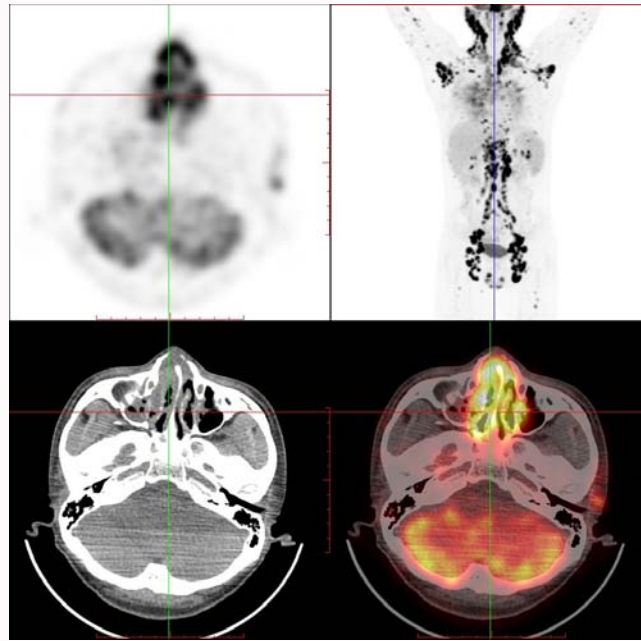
^{18}F -FDG PET/CT in a 25-year-old male with systemic TB: Hypermetabolic mucosal thickening of the nasal cavity and ethmoid sinus (SUVmax=16.7).
